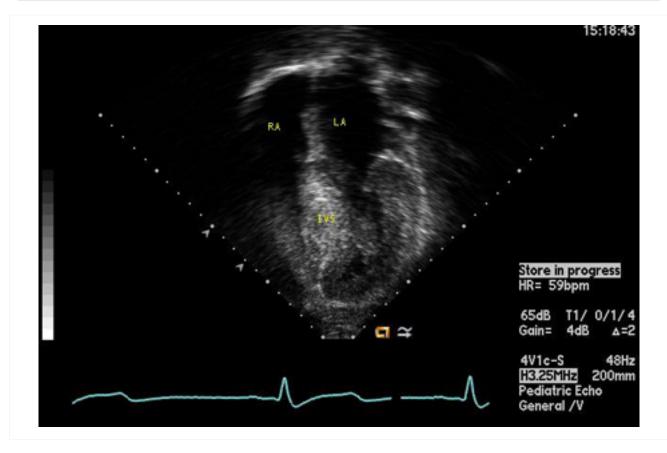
Apical 4-chamber image demonstrating hypertrophy of the interventricular septum From the collection of Dr Anji T. Yetman MD, University of Utah; used with permission
